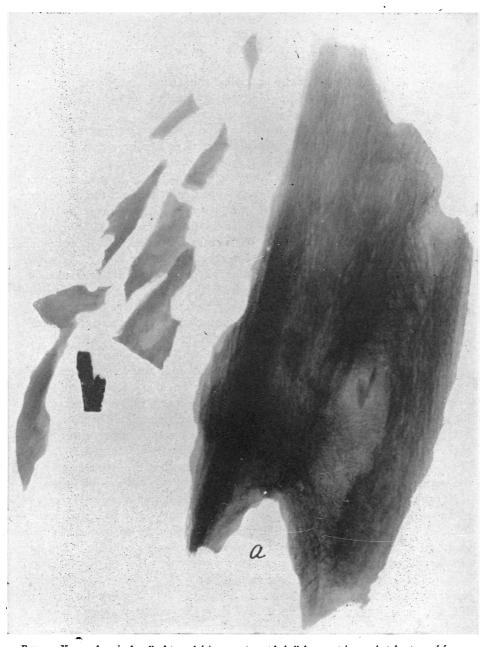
X-ray of excised wall of tunnel (a), sequestra and shell fragment in gunshot fracture of femur six and one-half months old. Atrophied cortex of most of wall is longitudinally streaked by dilated canals: sequestra compact.
